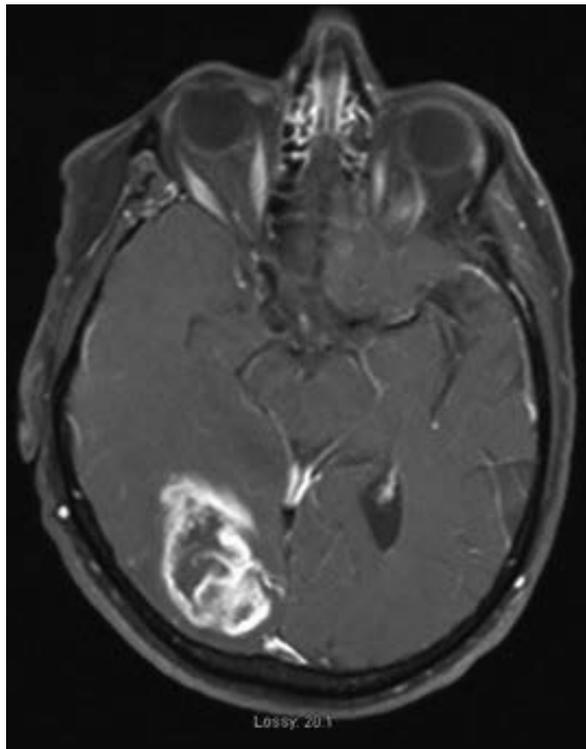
MRI scan of patient presenting with a left homonymous hemianopsia from a right occipital lesion.
